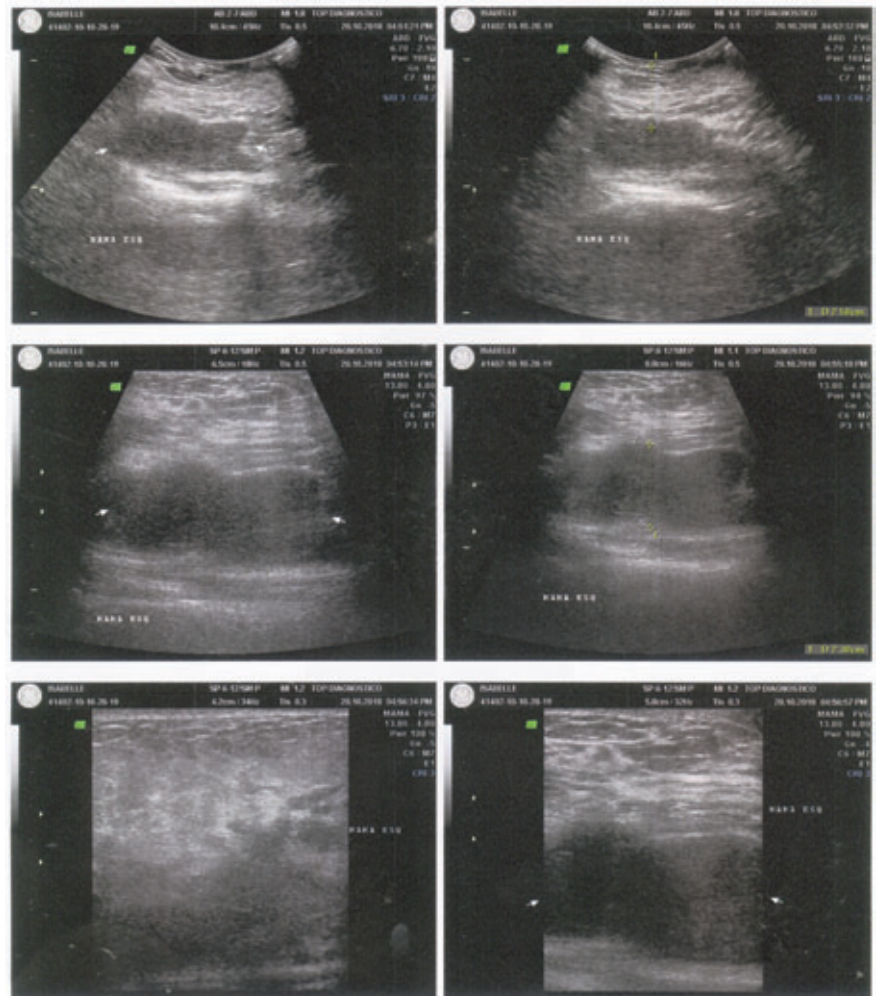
Left breast's ultrasonography showing fluid collection.
